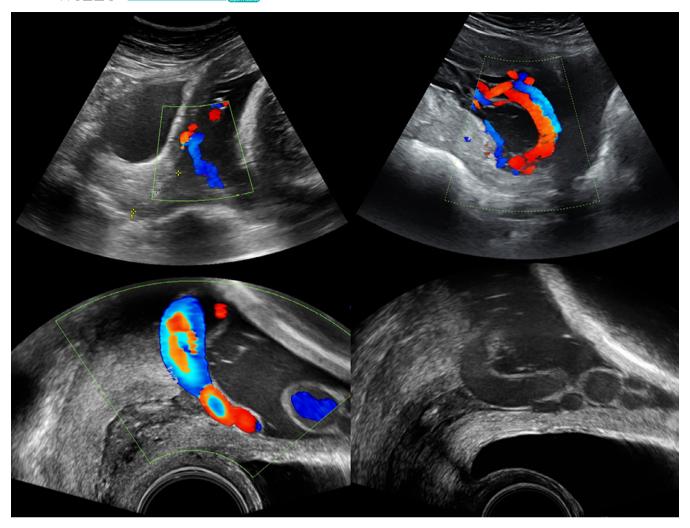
Case 1: Visualization using color-coded Doppler ultrasound of fetal vessels overlying the cervical os and a bilobed placenta (transabdominal)—ultrasound of the same case showing the bilobate placenta and the vessels crossing over the cervix (transvaginal)
